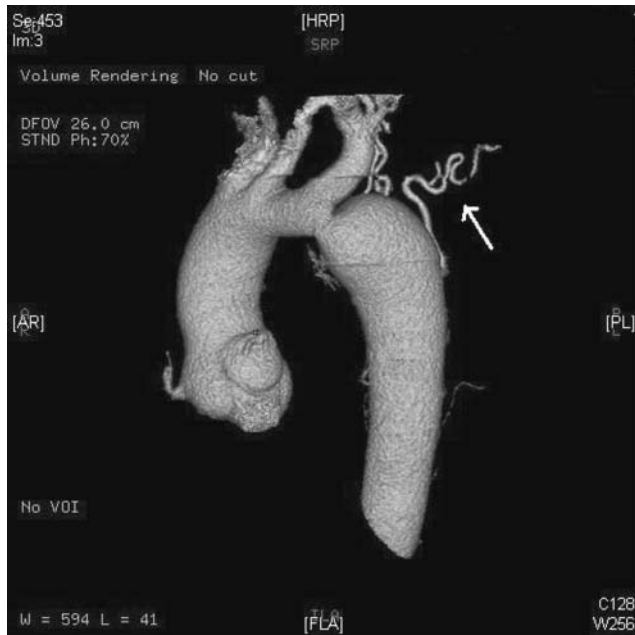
CT scan of an adult with unrepaired coarctation. Note the dilated aorta above and below the narrowed segment. Arrow indicates collateral vessels.
